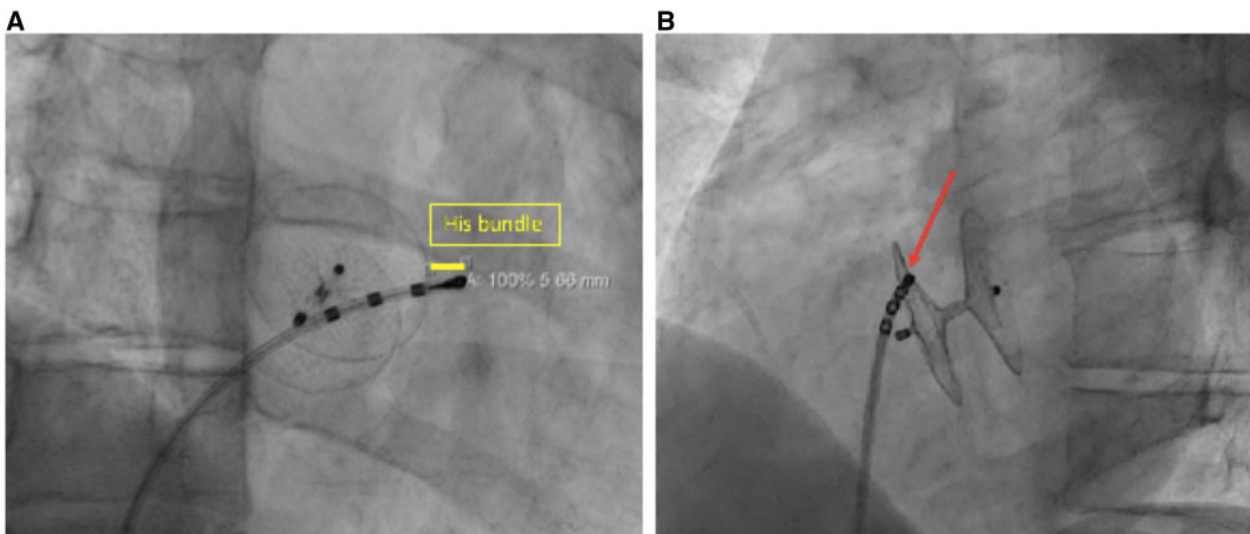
X-ray performed during the invasive electrophysiological study. (A) Right anterior oblique view showing the proximity of the catheter and the right atrial disc of the Amplatzer patent foramen ovale Occluder® device. Note the proximity of the device to the His bundle (yellow line). (B) The red arrow indicates the contact between the proximal electrodes of the catheter and the patent foramen ovale Occluder® device (left anterior oblique view).
